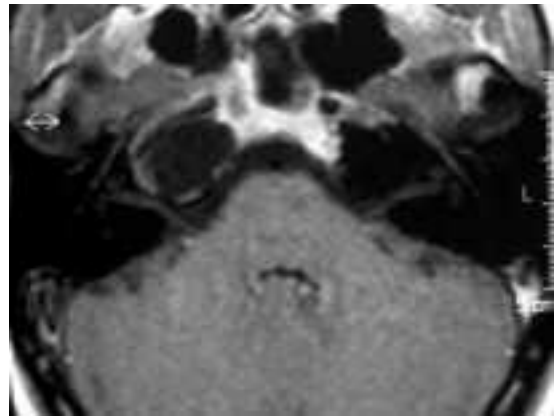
Axial MRI: on T1-weighted images with GDTPA only a very slight peripheral rim of enhancement is visible (white arrow). Mass does not take up Gadolinium and is hypointense to brain.
